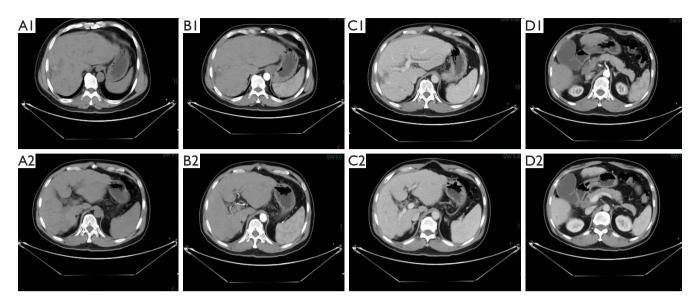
CT images at the last follow-up. The primary lesion was smaller than that before the (A1,A2) unenhanced CT scanning phase, the (B1,B2) arterial phase and (C1,C2) portal venous phase. (D1,D2) The size of the largest liver mass and partial portal lymph nodes was markedly decreased. CT, computed tomography.
